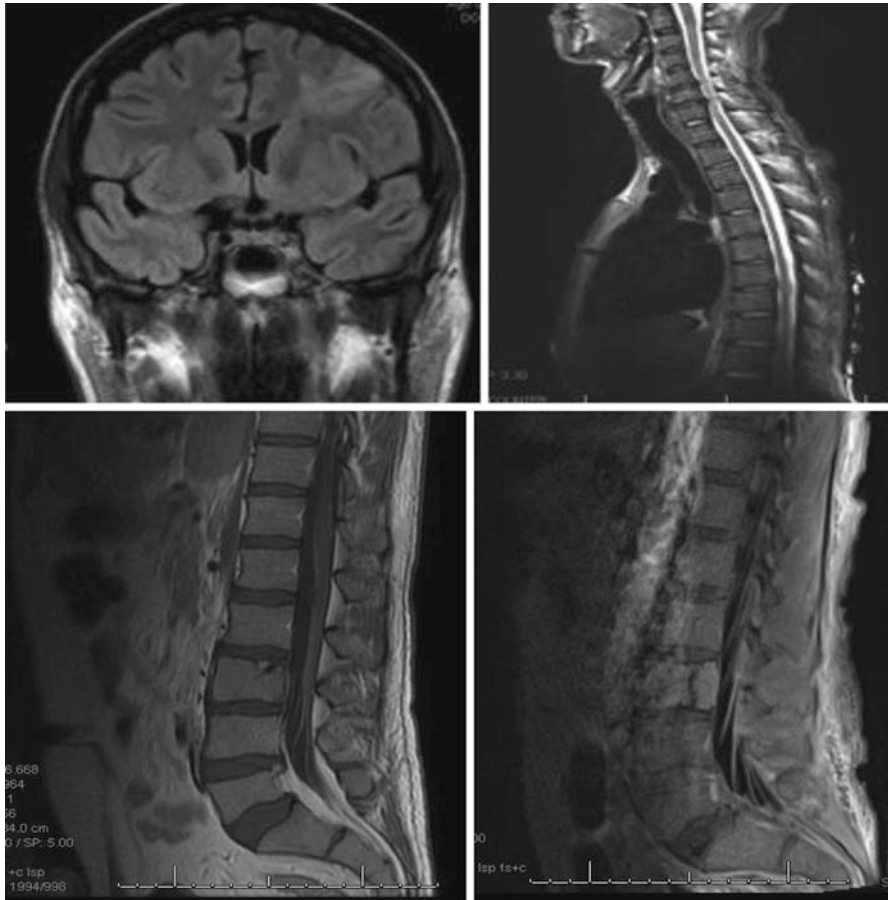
MRI Brain images for case Example 3. *Top Left:* MRI Brain showing left frontal stroke. *MRI C Spine* showing moderate stenosis without cord compression. *MRI Lumbar Spine* showing diffuse enhancement of nerve roots. The radiologist also reported an aggressive appearing lesion involving the L3 vertebral body concerning for tumor. The radiological differential diagnosis for this lesion includes primary lymphoma, inflammatory neuropathy, melanoma, primary bone tumor, and metastatic disease
